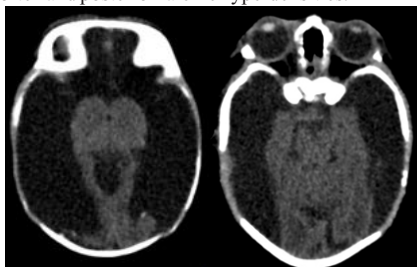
CT Brain axial sections (Brain window), RIGHT - Normal bilateral basal ganglia, thalami, LEFT - Normal Midbrain and cerebellum with remnant adjacent cortices.
